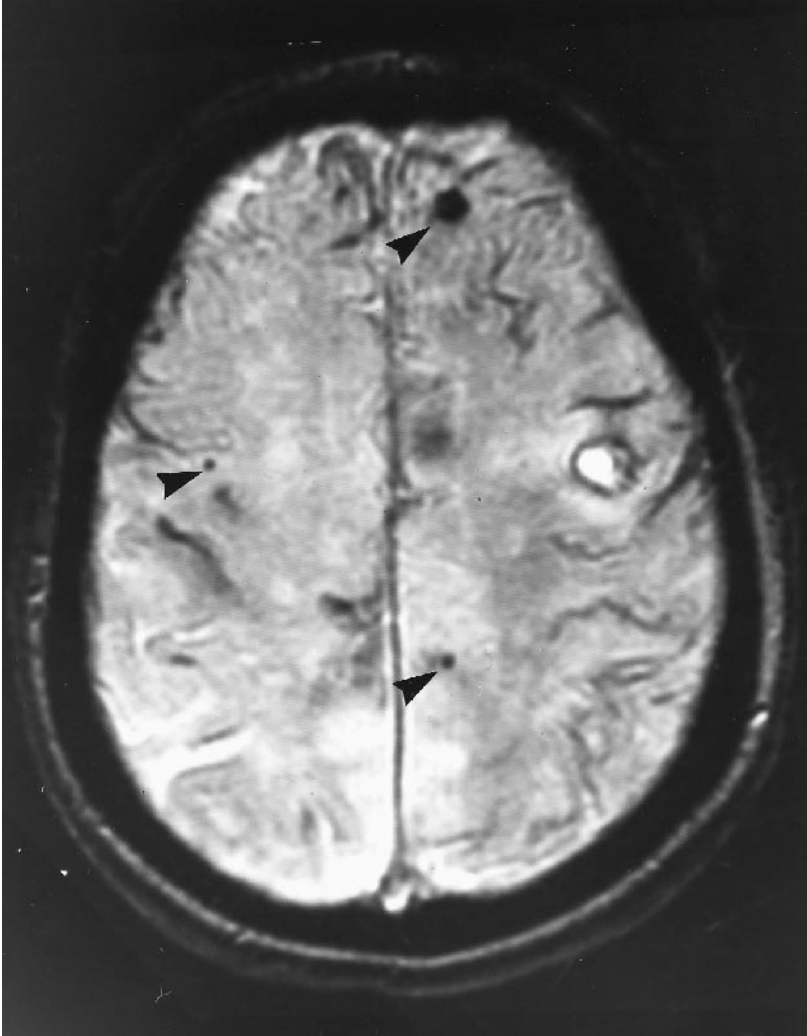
Amyloid angiopathy. Axial gradient echo sequence MRI shows an acute lobar hemorrhage in the posterior left frontal region with numerous areas of previous hemorrhage (arrows). The appearance of multiple areas of prior hemorrhage is not specific, but in an elderly patient is suggestive of cerebral amyloid angiopathy.
